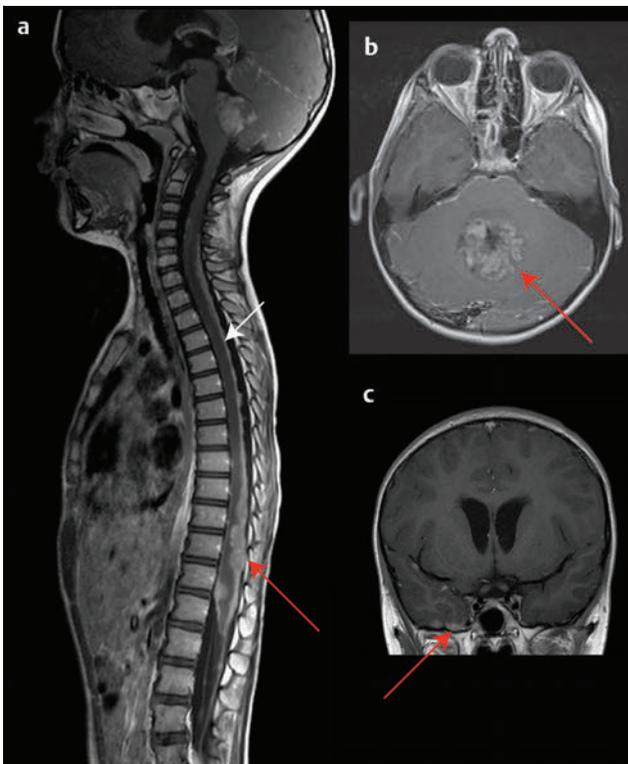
Metastatic medulloblastoma. (a) Sagittal T1-weighted gadolinium-enhanced magnetic resonance (MR) image of the entire spinal cord showing diffuse nodular (red arrow) leptomeningeal metastases throughout the entire spine. (b) Sagittal T1-weighted gadolinium-enhanced MR image of the lower thoracic and lumbar spinal cord showing a classic "sugar coating" pattern of laminar metastases (white arrow) covering the spinal leptomeninges. (c) Coronal T1-weighted gadolinium-enhanced MR image showing supratentorial nodular metastases (red arrow) along the inferior surface of the right temporal lobe.
